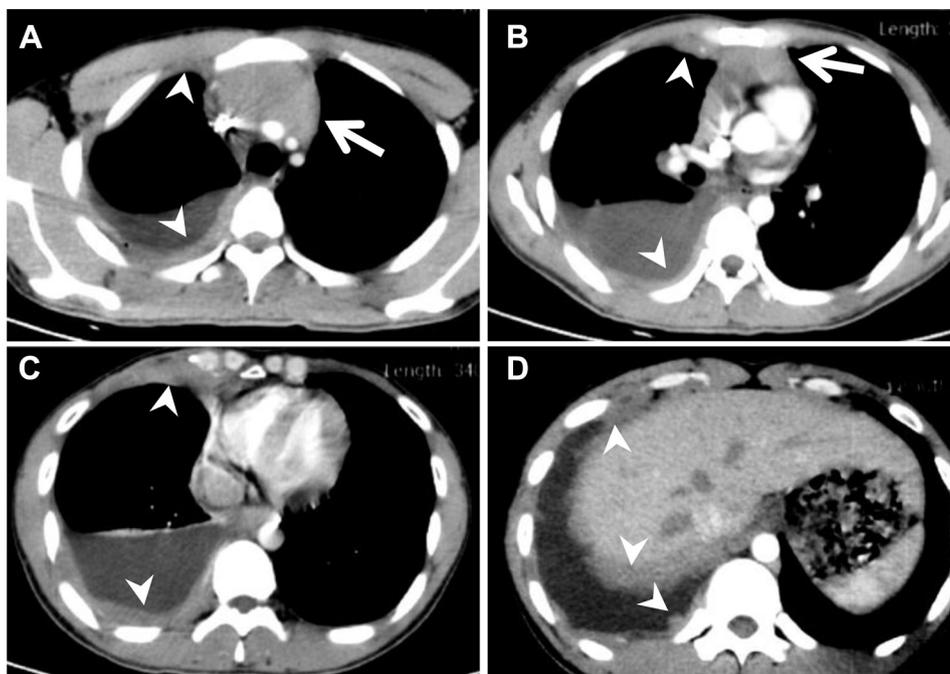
Chest enhanced computed tomography at different levels of the thorax (A-D) showed an ill-circumscribed tumor (arrows) of the mediastinum encasing the vessels and diffuse thickness of the right pleura (arrowheads) with effusion.
